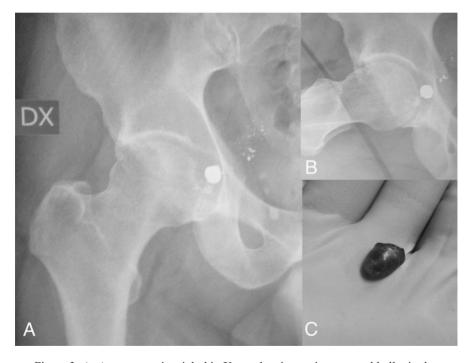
A: Anteroposterior right hip X-ray showing an incarcerated bullet in the acetabular fossa and metal fragment in the pelvis; B: Cross-leg hip view showing the central and deep location in the fossa; C: Intraoperative arthroscopic view showing the removed metal fragment of the bullet
